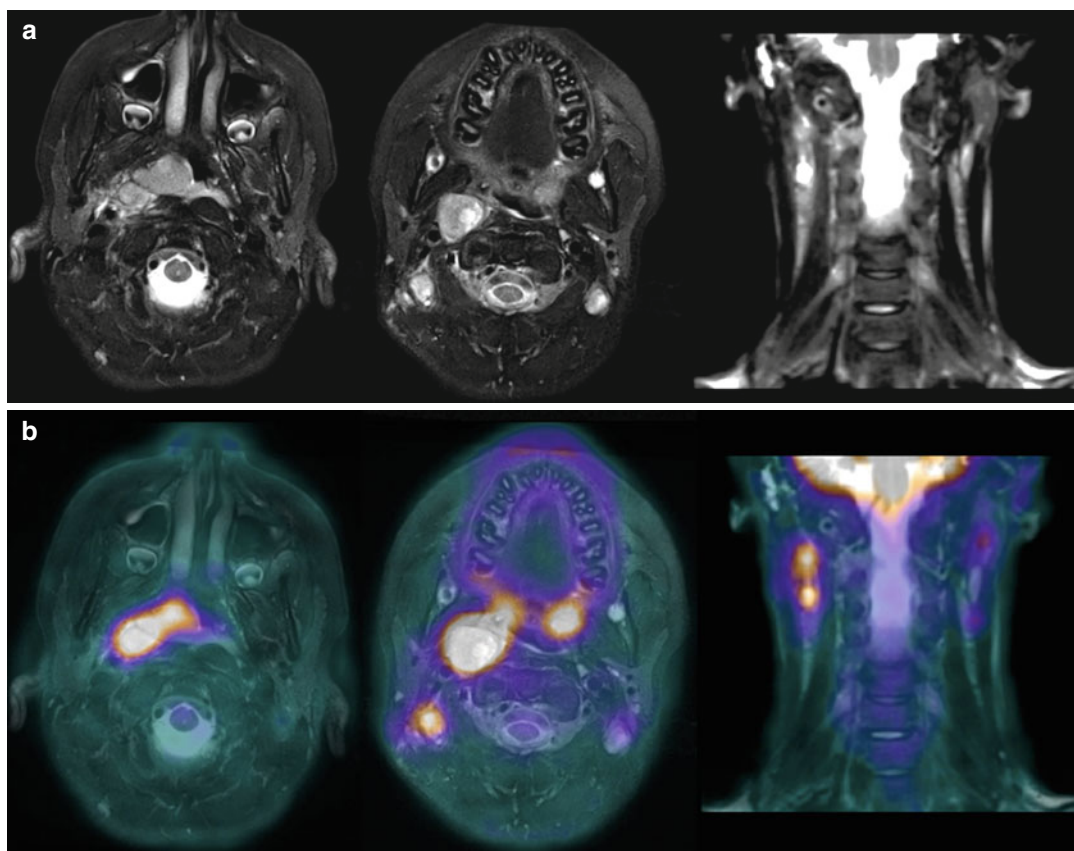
Nasopharyngeal carcinoma. A 15-year-old female presented with enlarged lymph nodes in the right cervical region. Biopsy revealed metastatic carcinoma. CT showed a mass in the right nasopharynx (not shown). MRI T2FS axial ((a) *top row* left to right) showed a large enhancing mass in the right nasopharynx, abnormal lymph nodes
